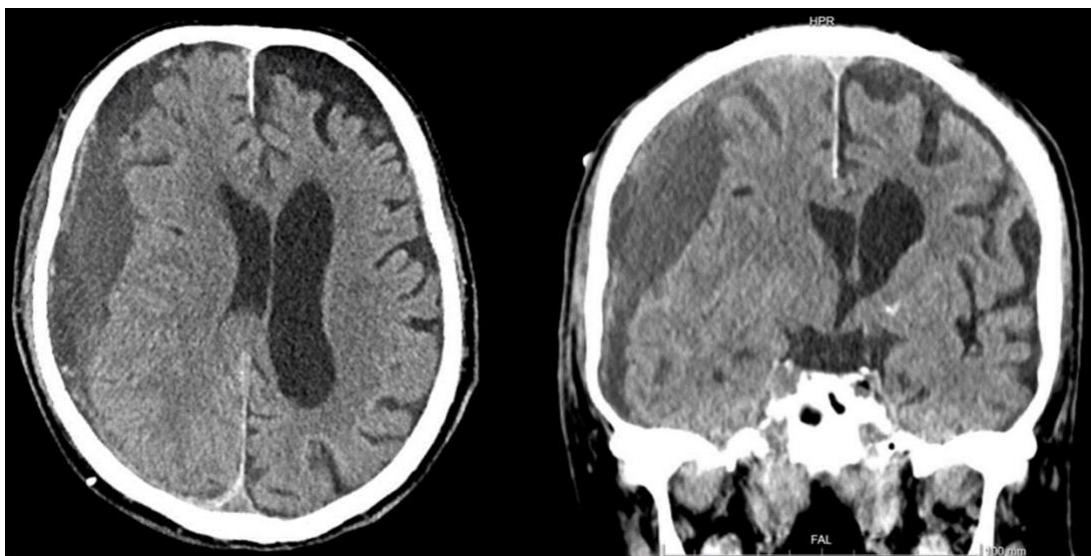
A hypodense chronic subdural hematoma on the right hemisphere on a CT scan in axial view (left) and coronal view (right). The hematoma has mass effect and forces the midline structures to the left causing subfalcine herniation.
